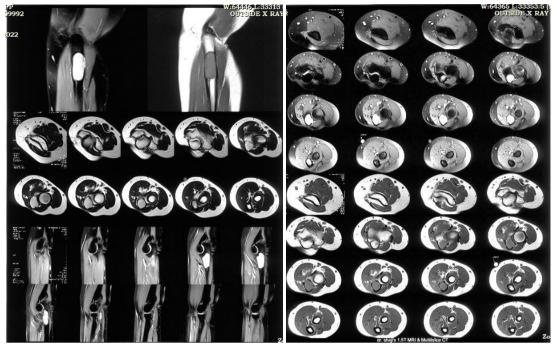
MRI of elbow joint showing expansile lytic lesion with multiple incomplete septations
